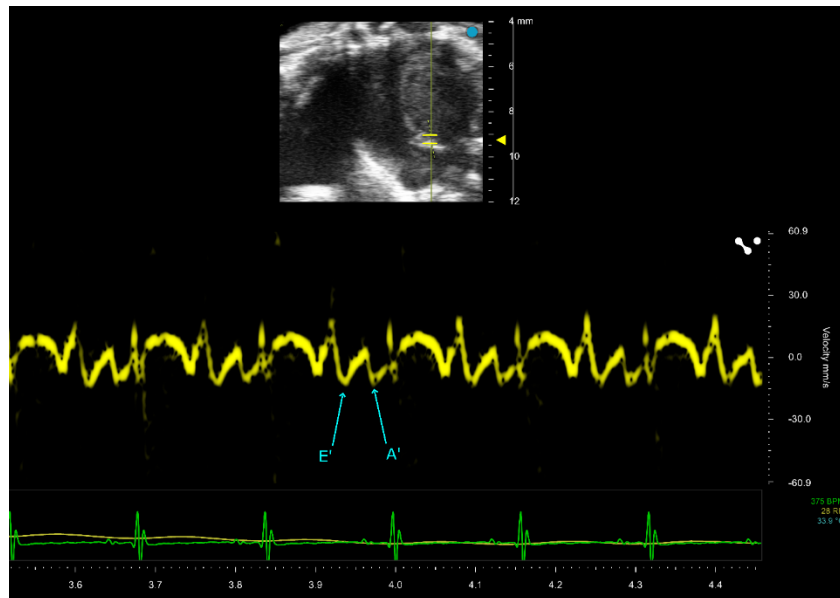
Mitral Valve tissue doppler waveform
